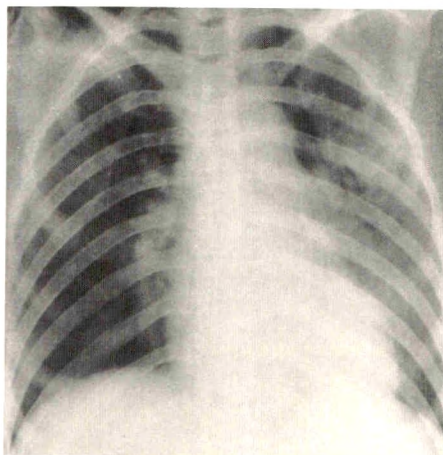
18-year-old woman drank 50 .nl of 80% DDVP in an attempted suicide. A chest radiograph made 30 min later shows bilateral pulmonary edema and cardiomegaly, which cleared in 4 days.
